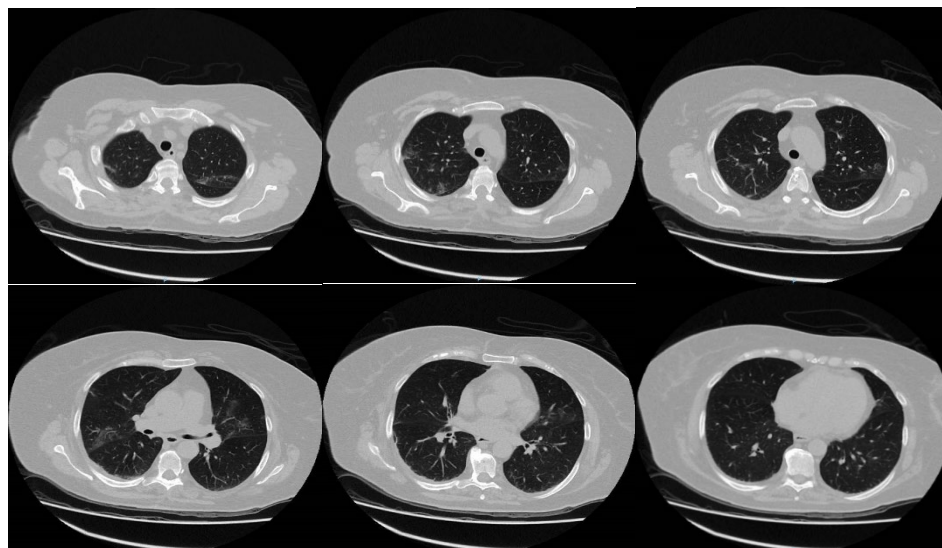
Chest CT performed at discharge (28 days after COVID-19 diagnosis) showing a gradual resolution of the multilobar pneumonia with remaining abnormalities (multiple ground glass opacities with predominant peripheral distribution, associating interlobular septal thickening and fine fibrotic bands).
